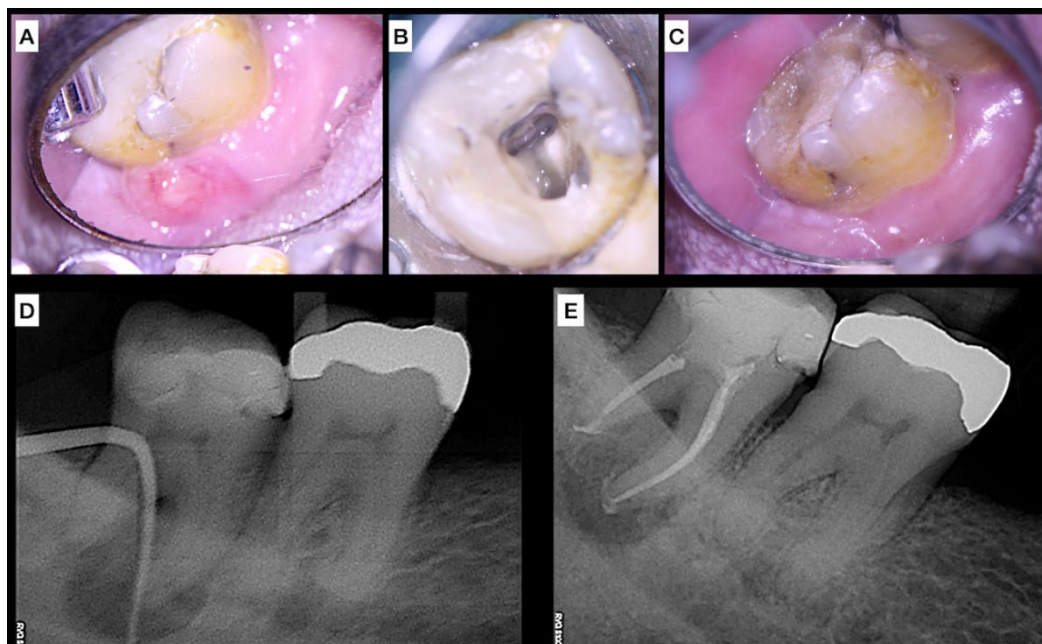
Treatment of case 2, A) Preoperative clinical aspect (sinus tract); B) Access Cavity; C) Absence of the sinus tract 14 days after the first session; D) Preoperative periapical radiograph; E) Immediate postoperative periapical radiograph
